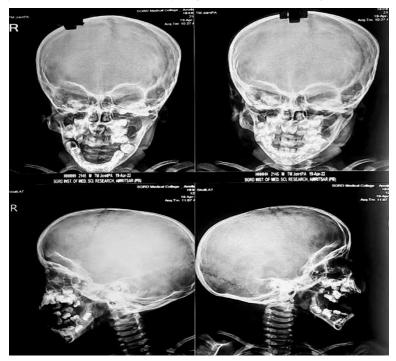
X-Ray facial bones PA & lateral views, shows bilateral bony outgrowths arising from the maxilla(white arrows).Note is also made of maxillary supernumrery teeth (dotted arrow).
